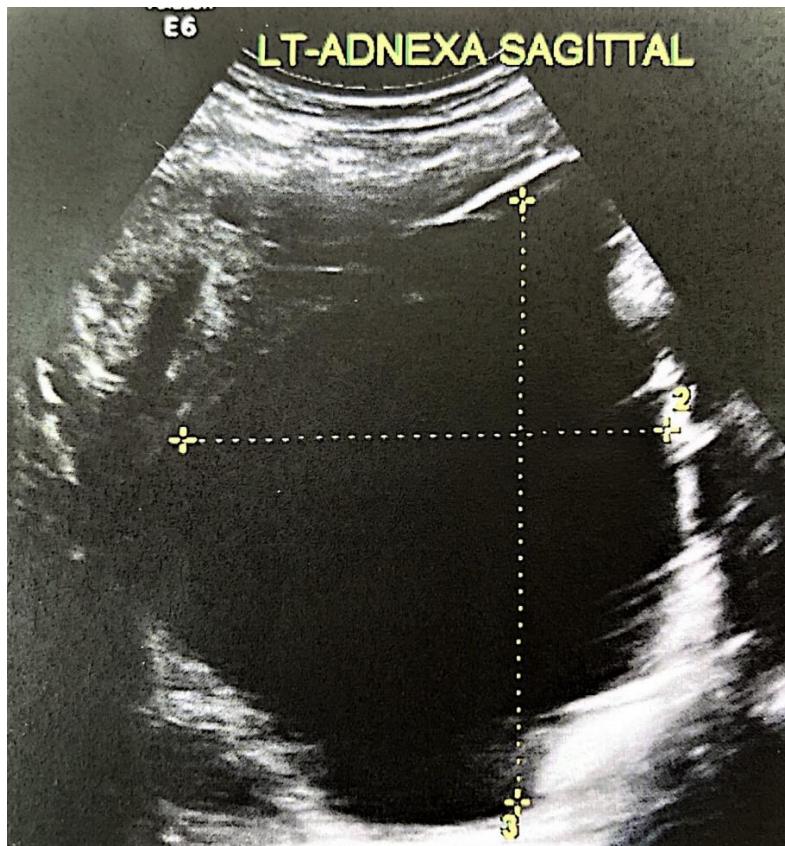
Ultrasound of left ovarian cyst showing a simple, uniloculated cyst.
